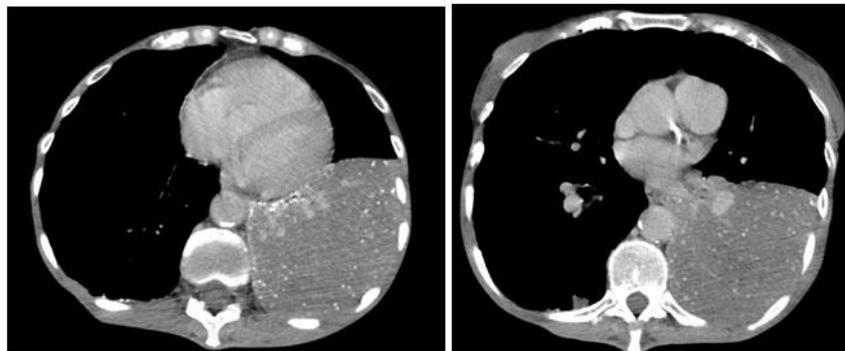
A thoracic contrast-enhanced computed tomography in axial sections and mediastinal window showing an alveolar consolidation of left lower lobar, with innumerable tiny and calcified nodules related to her disease (Intravascular talcosis). Consolidation of left lower lobar
